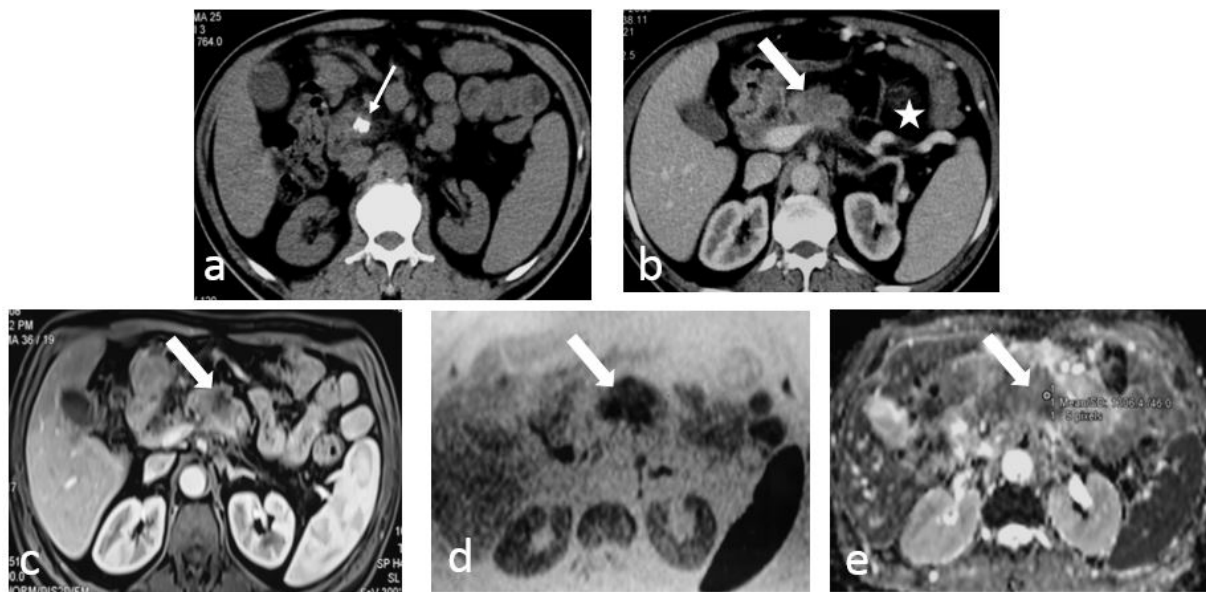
Axial non-contrast CT (a) of a patient with CCP who presented with worsening of pain shows calcification in the head of pancreas (thin arrow) with parenchymal atrophy. Axial CECT (b) shows a hypoenhancing mass lesion in the body of pancreas (thick arrow) causing contour bulge. Multiple peripancreatic collaterals are also seen (asterisk) which are due to narrowing of the splenic vein. Post contrast MRI (c) confirmed this hypoenhancing lesion (thick arrow). Diffusion weighted MRI (d) using b value of 1000 with inverted grey scale shows profound hypointensity and the focal lesion is hypointense on ADC map (e) also (thick arrow). These imaging features are suggestive of pancreatic carcinoma in the background of CCP and this was confirmed on cytology.
